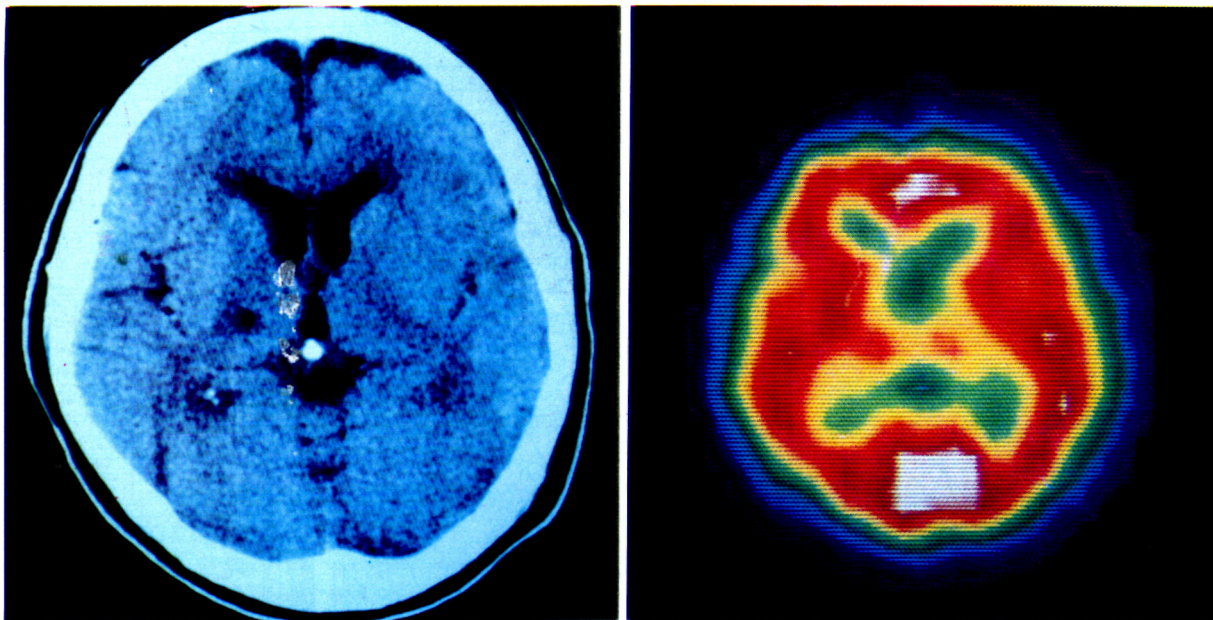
CT (left) revealed a lacune in the right thalamus, whereas a SPECT image with attenuation correction (right) showed no abnormality.
